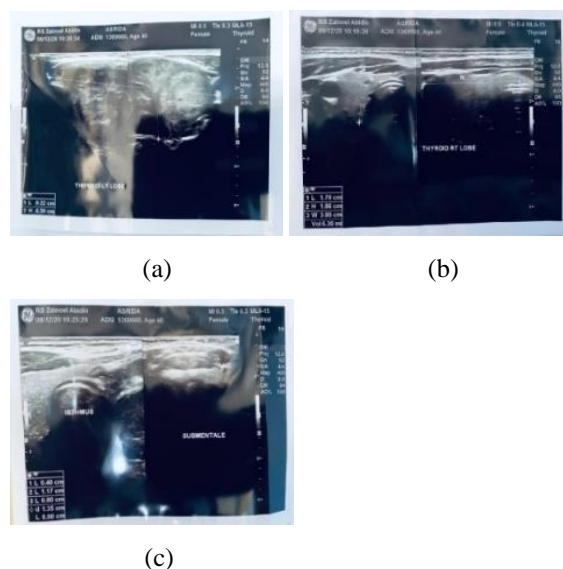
Ultrasound shows (a) multiple lesions of the right thyroid, (b) enlargement of the left thyroid and multiple lesions of the left thyroid (c) Multiple nodules of the isthmus.
